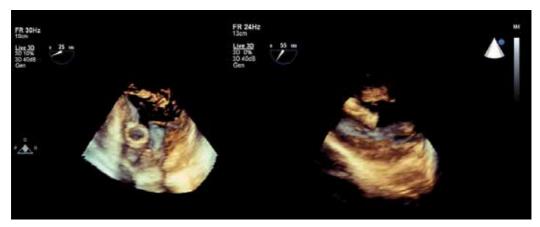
Live 3D transoesophageal echocardiographic images of a left ventricular VAD cannula
